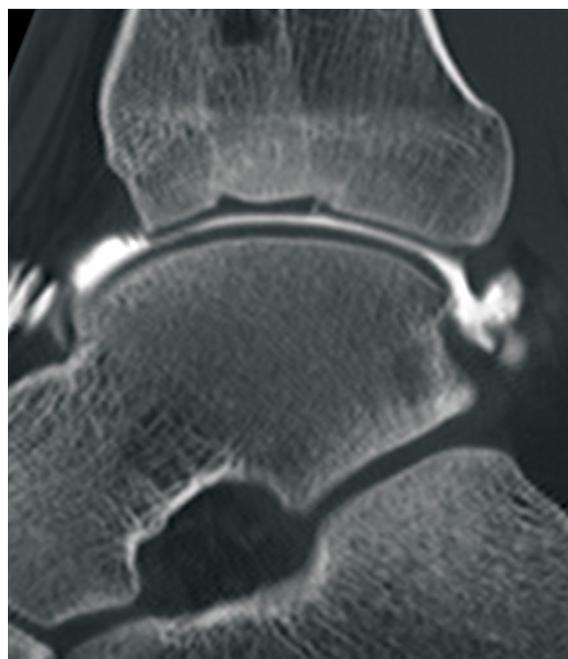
Sagittal computed tomography of the first osteochondral graft at one-year follow-up.
